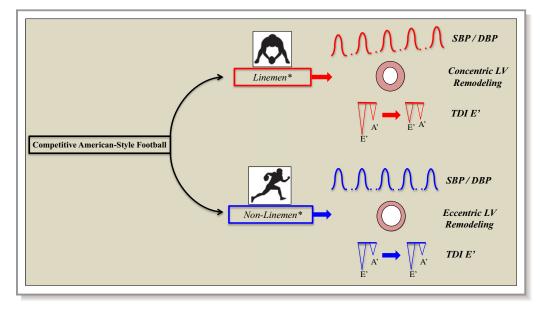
Generalized differences in American-style football cardiovascular phenotypes by player position. *Lineman positions are offensive tackles, guards, and center and defensive tackles and ends; nonlineman positions are quarterback, running backs, receivers, defensive backs, linebackers, and special teams. A' indicates late mitral annular relaxation velocity; DBP, diastolic blood pressure; E', mitral annular early relaxation velocity; LV, left ventricle; SBP, systolic blood pressure; TDI, tissue-Doppler imaging.
